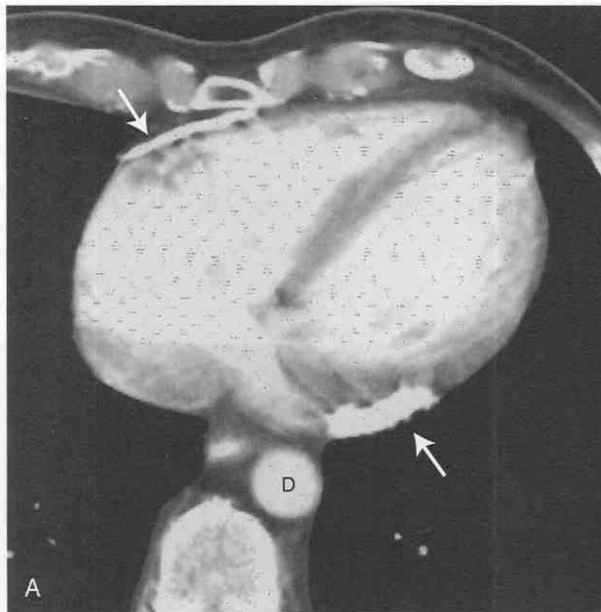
Constrictive pericarditis. *A*, Axial contrast-enhanced CT image at the level of the ventricles shows bilateral dense calcification of the pericardium at the level of the atrioventricular grooves (*arrows*). *B*, Scan at the level of the left atrium shows an additional area of calcification anteriorly (*arrow*). The superior vena cava is larger than the descending aorta. *C*, Scan at the level of the diaphragm shows inferior pericardial calcification (*arrow*). The inferior vena cava is more than twice the size of the descending aorta. A, aortic root; D, descending aorta; I, inferior vena cava; LA, left atrium; RV, right ventricular outflow track; S, superior vena cava.
